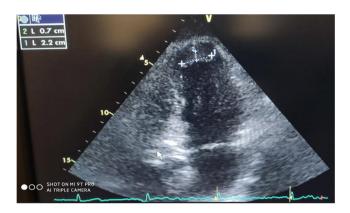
Echocardiogram indicating a reduced-sized left ventricular clot (EF=45%-50%).
